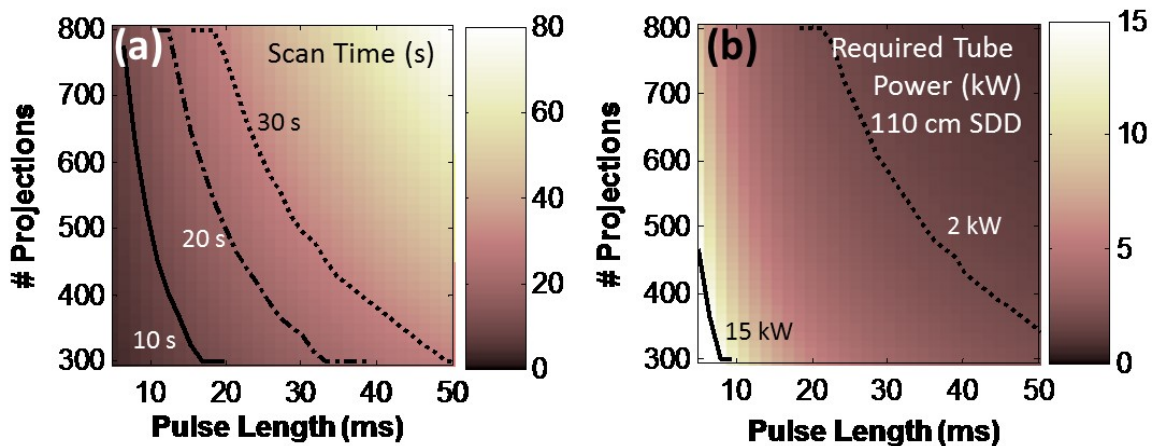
Analysis of additional practical considerations of the x-ray source power, pulse width, scan time, and FOV. (a) Total scan time computed as a function of the number of projections and x-ray pulse width, assuming 20 mGy dose and nominal system geometry. (b) X-ray tube power (giving 20 mGy dose) computed as a function of the number of projections and pulse length.
